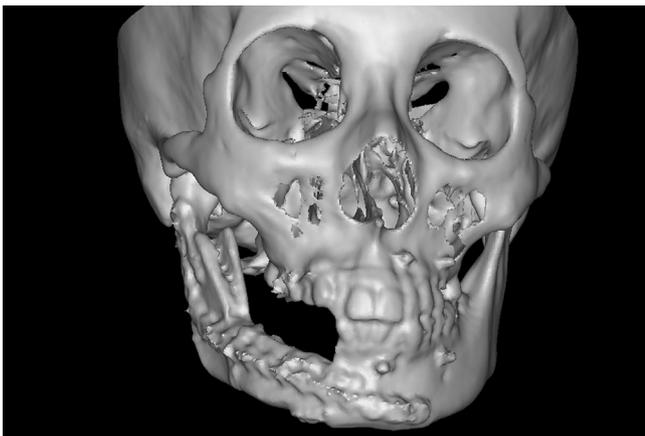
Postoperative 3D CT scan showing the reconstruction contour of the mandible and bone with sufficient length and vertical height.
